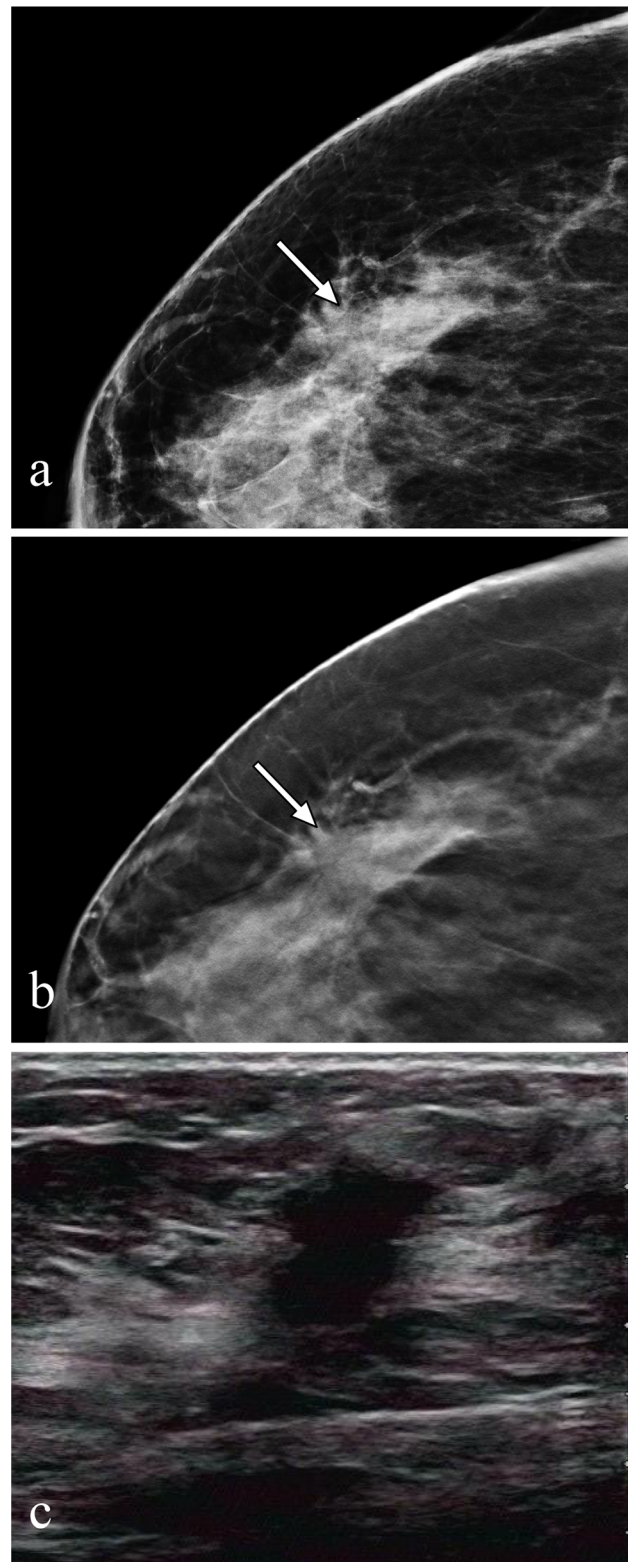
Craniocaudal and ultrasonography images in a 62-year-old woman with ductal carcinoma in situ with micro-invasive in the right breast. a DM image. b DBT image. c US image. The spiculated mass margins are better shown in b than in a. US c showed a typically malignant findings
